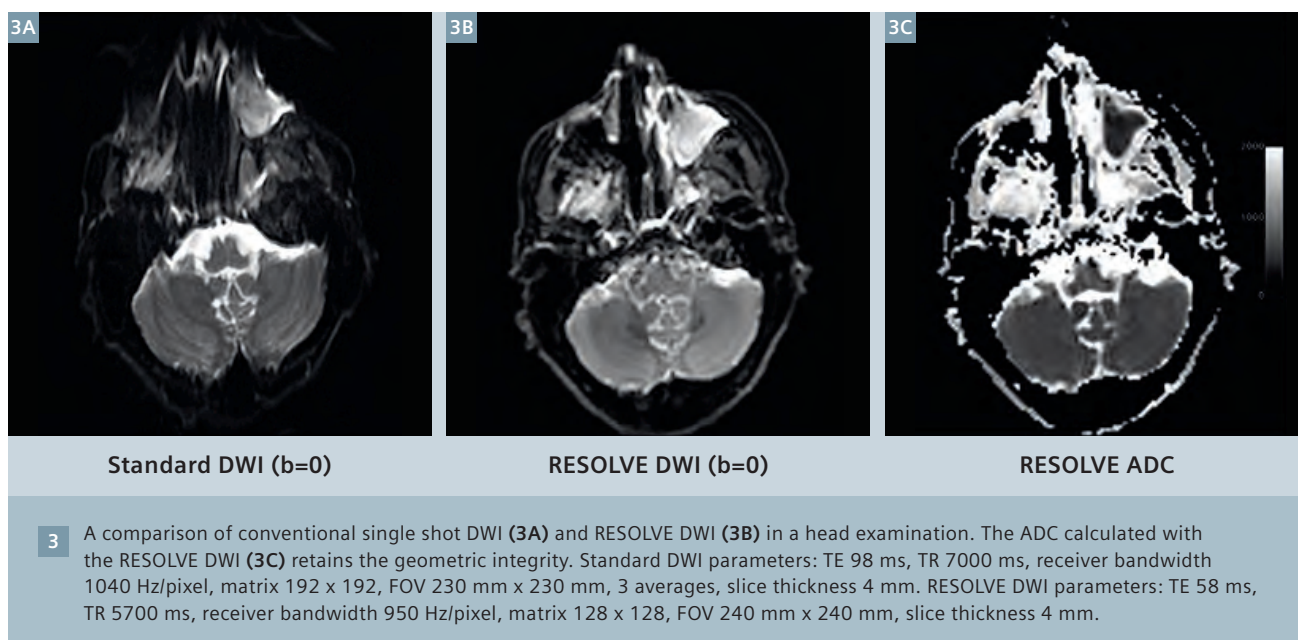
compares DWI acquired without and with the RESOLVE technique for a Head subject, in a slice comprising air spaces. The clear improvement in geometric integrity achieved with RESOLVE DWI allows the registration of anatomical and functional images, thus allowing the use of DWI in RT planning for Head and Neck cancers (Fig. 4).
